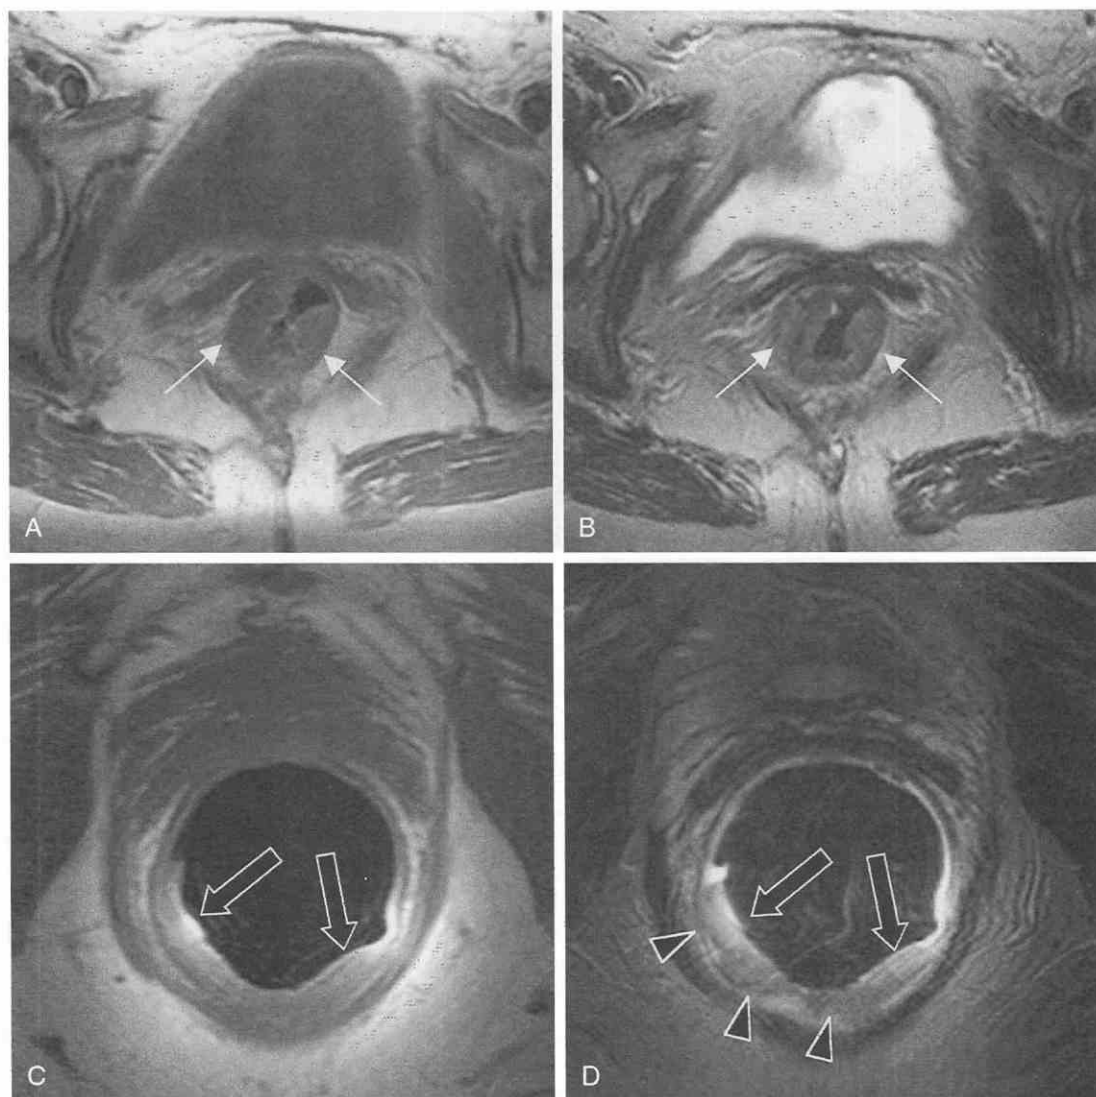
Pelvic and endorectal coil imaging of rectal carcinoma. *A*, T1-weighted, spin-echo multicore image shows hemicircumferential thickening of the rectal wall (arrows). *B*, T2-weighted, fast spin-echo image again demonstrates intermediate-signal-intensity thickening (arrows) compatible with tumor. The muscularis, however, is not well identified. *C*, T1-weighted, spin-echo, endorectal coil image shows the tumor in the right and left lateral walls of the rectum (arrows). *D*, T2-weighted, spin-echo image shows the intermediate-signal-intensity tumor (arrows) and invasion of the muscularis underlying the tumor (arrowheads).
